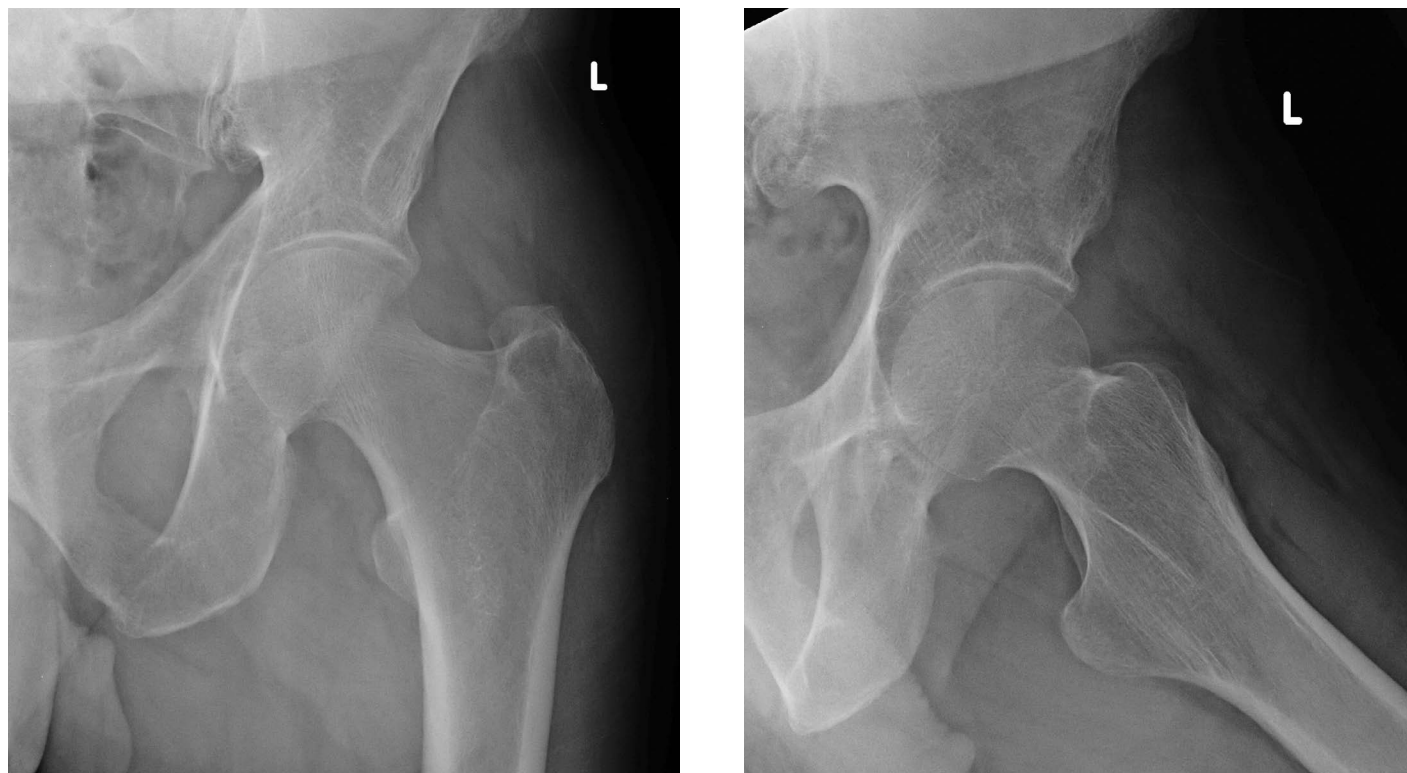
Anteroposterior (A) and frog-leg lateral (B) radiographs reveal normal bone density, trabeculae and only minor hip joint space narrowing.
